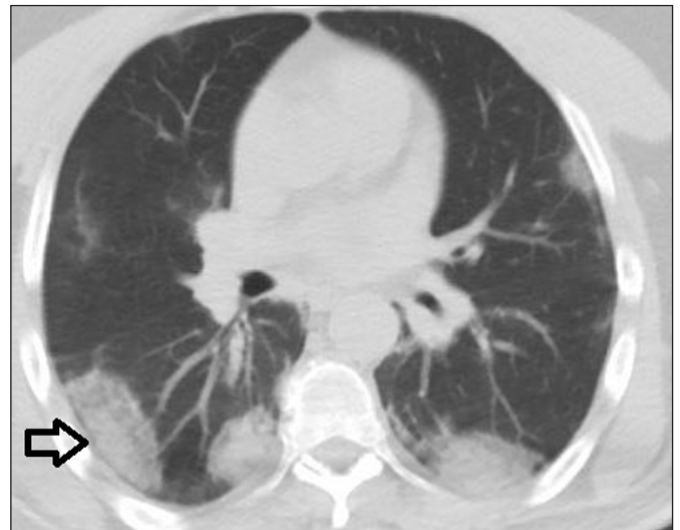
CT image shows round peripheral consolidation with GGOs in the bilateral lower lobe
